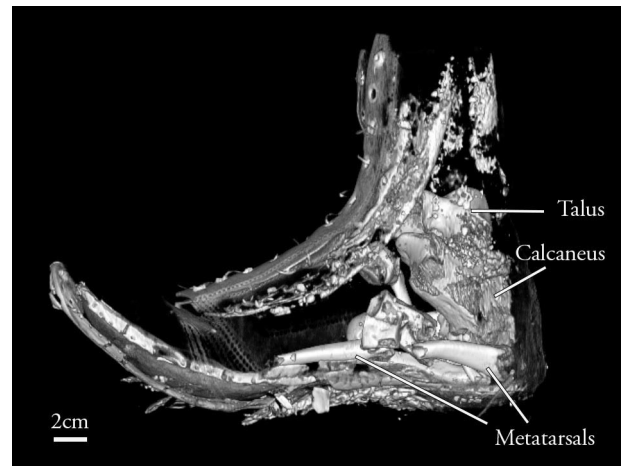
A computed tomography 3D rendering of the left boot with bones still inside.
